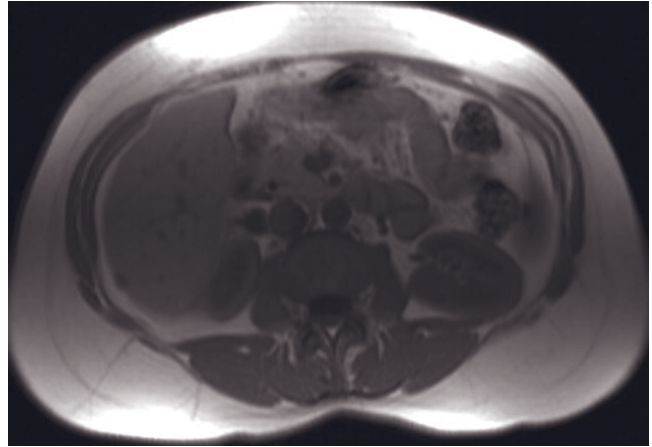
(Continued) into the porta hepatis, that demonstrates high signal on T2-weighted images (*f*, *g*, *b*) and low signal on T1-weighted image (*i*). Immediately after gadolinium administration (*j*), multiple peripheral enhancing nodules are identified that enlarge and coalesce on later images (*k*), consistent with an exophytic hemangioma. On an outside CT examination this was thought to arise from the pancreas. The coronal T2-weighted image (*g*) demonstrates inferior displacement of an intact pancreas (arrow, *g*). Additionally, the pancreas distal to the mass exhibits normal high signal on the T1-weighted fat-suppressed image (*i*), which essentially excludes a pancreatic adenocarcinoma.
